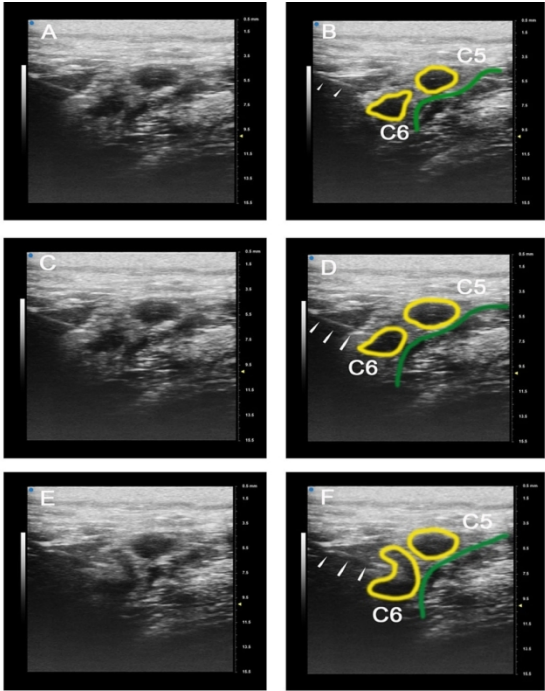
Ultrasound images of the right interscalene C6 ventral nerve root in soft embalmed Thiel cadaver no. 8, imaged using a 22- 45Mz microultrasound transducer. The scale on the right-hand side is from 0.5 to 15.5mm. Image pairs are show without (left) and with (right) annotation indicating needle position (arrowheads), C5 and C6 nerve roots outlined in yellow, and scalenus anterior muscle outlined in green. Images A and B shows the needle approaching the nerve. The tip is approximately 2 mm from the epineurium. Images C and D shows the needle touching the epineurium. Images E and F shows the needle tip indenting the epineurium.
